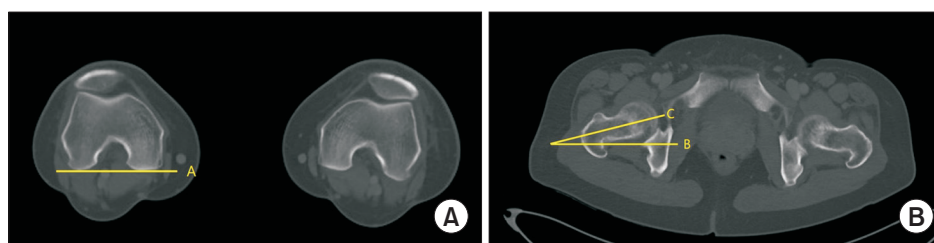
(A) Computed tomography through the posterior femoral condyle of the distal femur. Line A is the line connecting both posterior condyles. (B) Computed tomography through the widest femoral neck. Line B is a parallel line of line A. Line C is a line passing through the center of the femoral neck. The angle between line B and C is femoral version.
